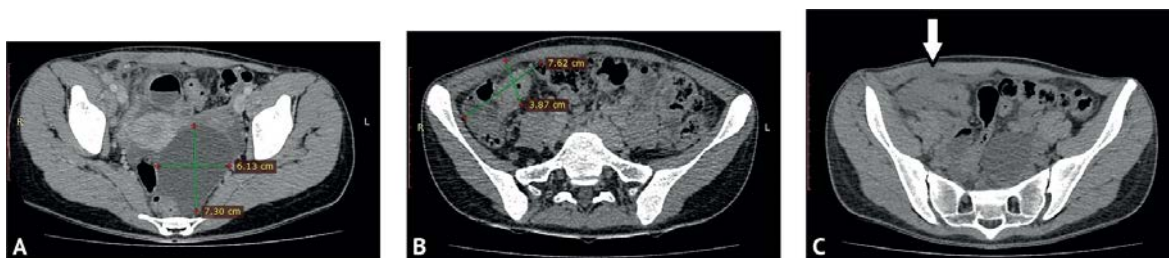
CT scans of the patient's small pelvis at different levels: A — the size of the paraovarian cyst on the left is indicated; B — the size of the infiltrate of the right iliac fossa; C — the white arrow indicates the place of deformation (destruction) of the tissues of the anterior abdominal wall in the area of contact with the infiltrate
